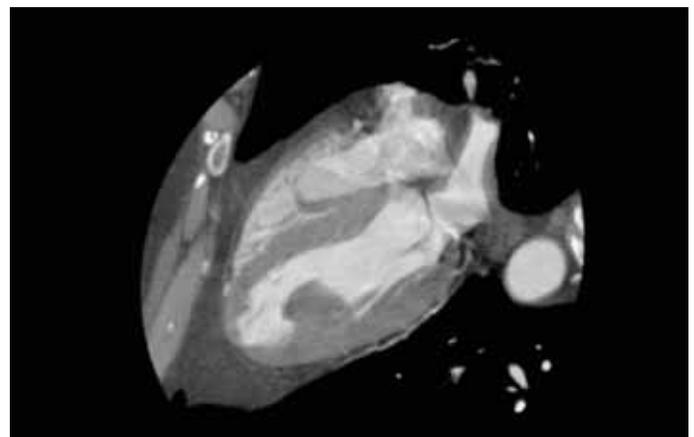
Cardiac CTA showing intracavitary left ventricular mass.
